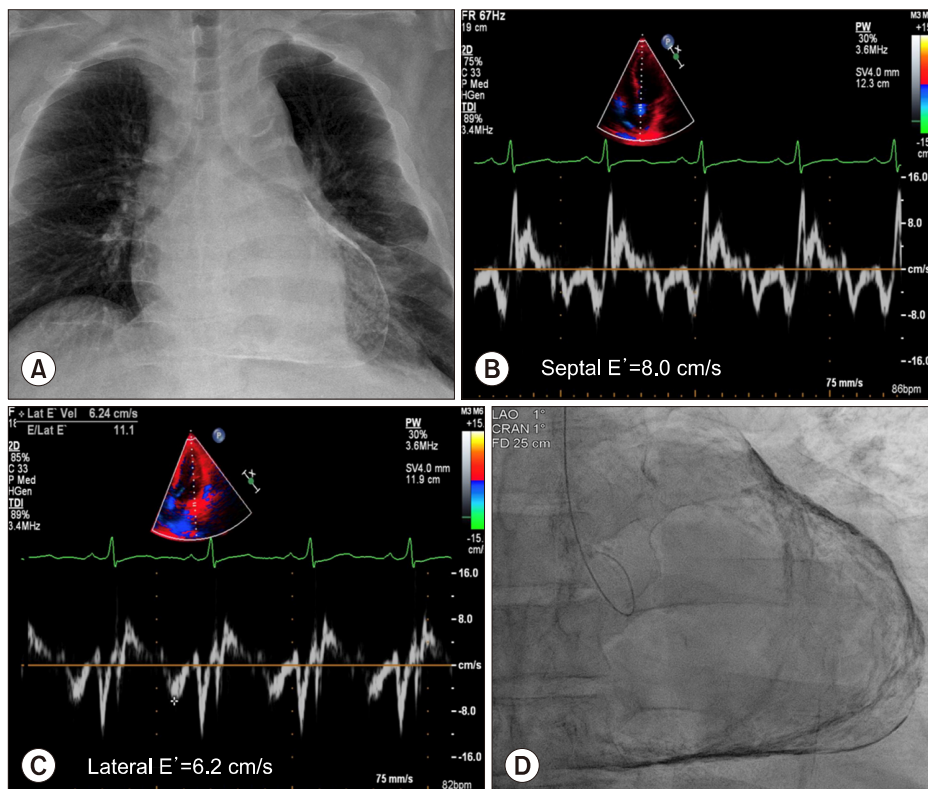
(A) A chest radiograph showing extensive pericardial calcification. Doppler echocardiography demonstrating “annulus inversus,” a reversed ratio of (B) septal (8.0 cm/s) and (C) lateral (6.2 cm/s) annular myocardial velocities in early diastole suggesting pericardial constriction. (D) Fluoroscopic imaging showing an extensive “eggshell” calcification of pericardium.
